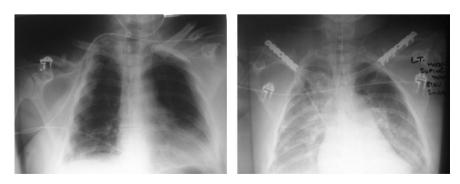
Radiographs showing fractures of all 24 ribs and the clavicles, along with bilateral haemopneumothorax.
